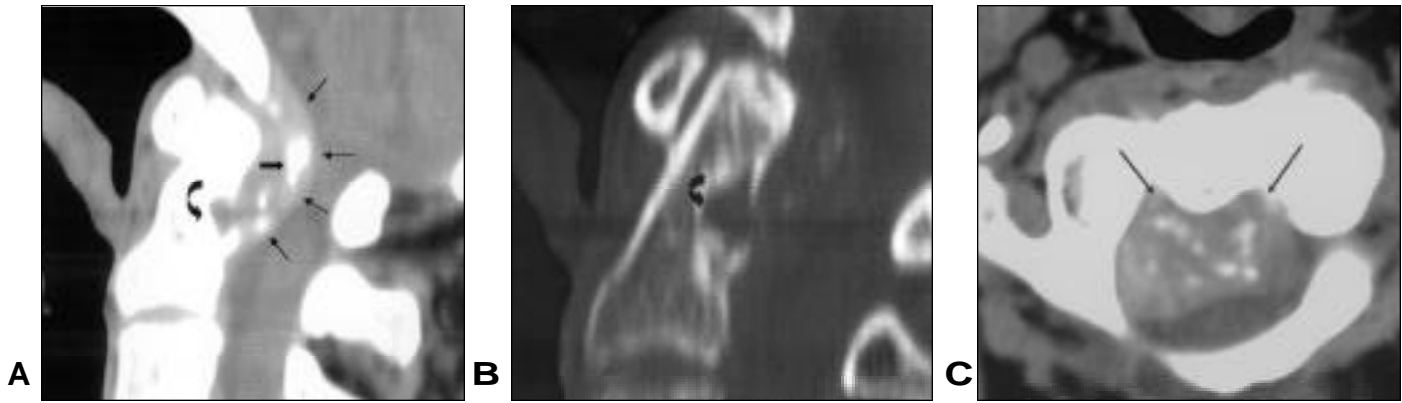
Sagittal reconstruction CT image (Figure 1a) reveals a mildly hyperdense mass (thin small arrows) in the retro-odontoid area with foci of calcification (small broad arrow). Erosion with remodeling is noted at the posterior aspect of the dens (curved arrow-Figure 1a and b). Axial CT image (Figure 1c) shows the mass (arrows) compressing the cervical cord posteriorly.
